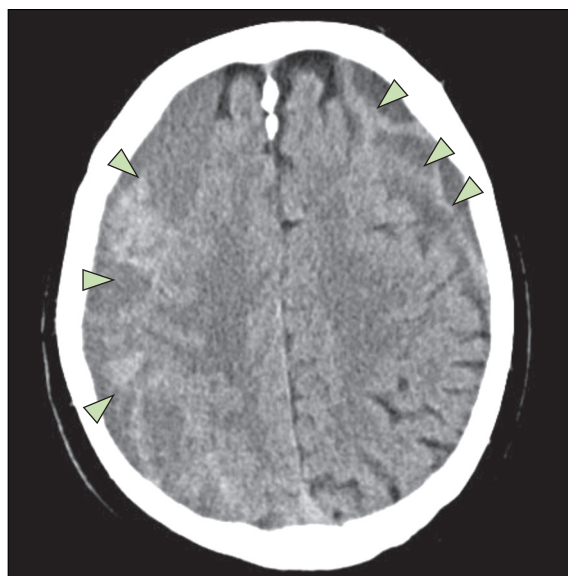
An 83-year-old man with history of recurrent falls found unresponsive at home. Non-contrast brain CT shows bilateral and partially isodense, especially on the right (left-hand side of the image) subdural haematomas (green arrowheads). He was treated effectively with urgent burr holes.
